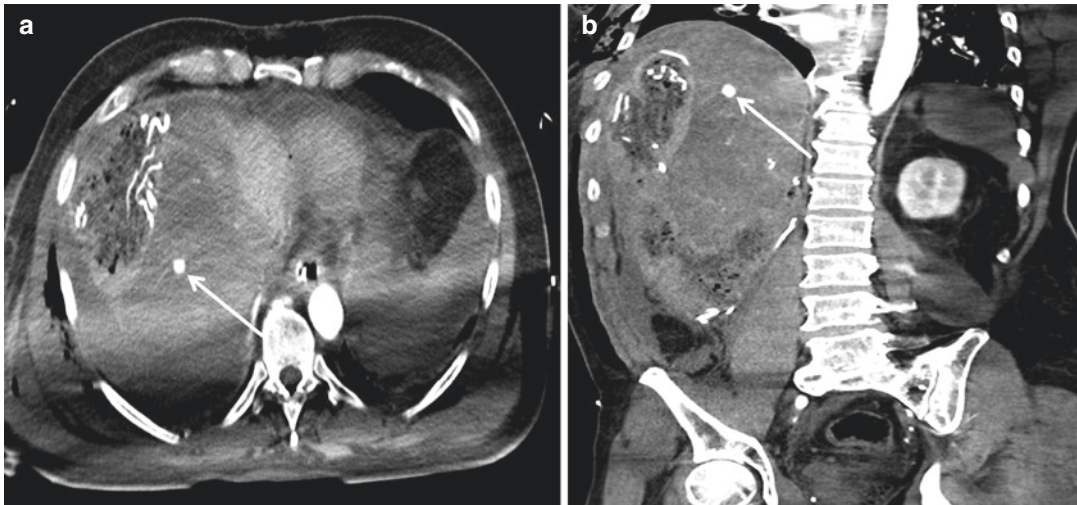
Hepatic trauma treated by surgical packing. (a) Axial CT scan and (b) coronal reconstruction show a pseudo-aneurysm: it appears as a focal lesion with high attenuation values in the arterial phase (*arrows*)
